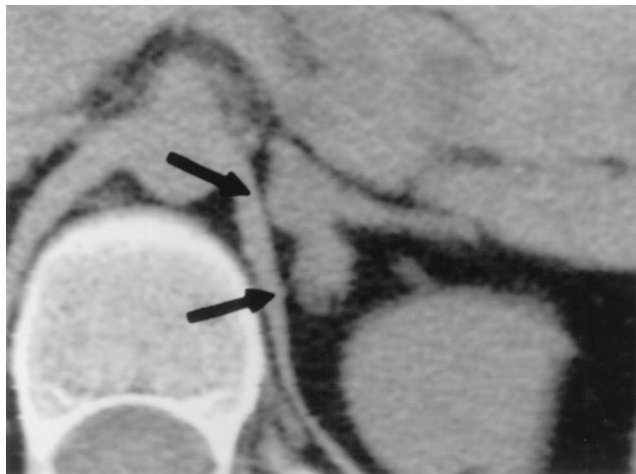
Macronodular appearance on computed tomography of the adrenal gland in a patient with primary pigmented adrenocortical disease (left) and the more typical "bead-on-a-string" appearance of an adrenal gland in a patient with primary pigmented nodular adrenocortical disease (right).
